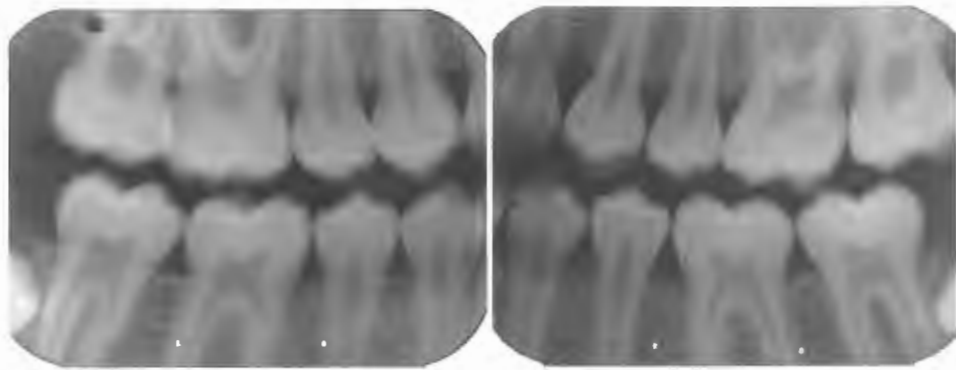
Bite-wing radiographs of a female (Case 12) affected by VDRR. The dental manifestations were of Grade I severity with near-normal calcification of the teeth. Note normal sizes of the pulp chambers.
